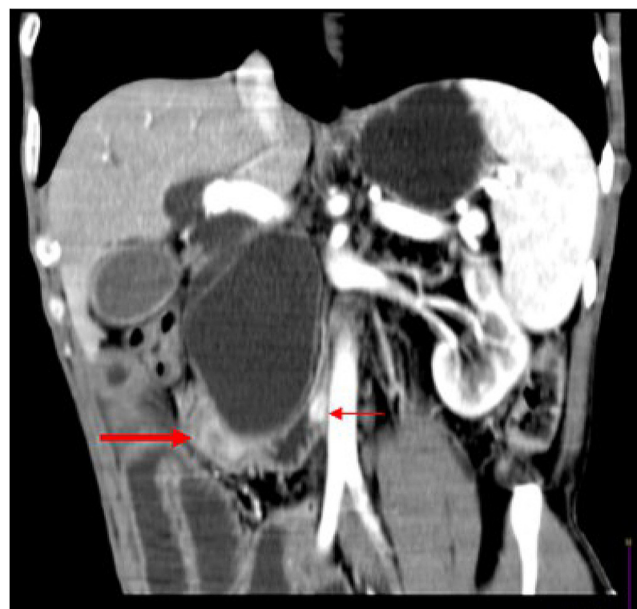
This coronal CT image of patient 1 nicely reveals the large periampullary mass (large arrow), the contrast-enhanced duodenal GIST (small arrow) and a dilated gallbladder.
